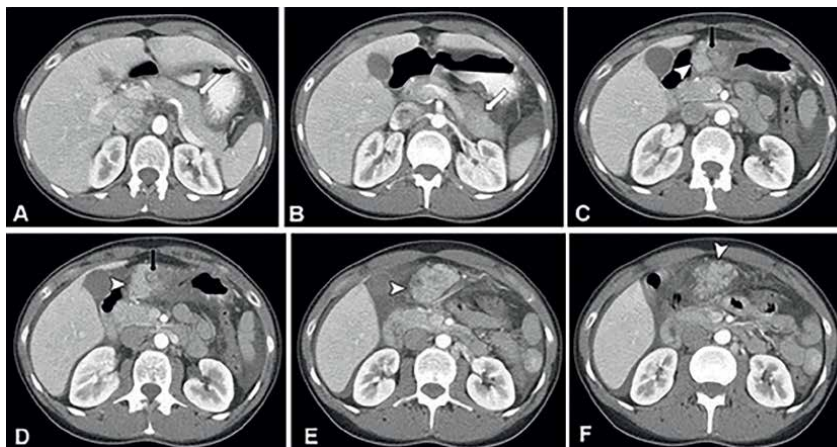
Heterotopic pancreas complication as acute pancreatitis in a 28-year-old woman with complaint of abdominal pain and nausea (elevated serum lipase level of 1300 U/L). Axial contrast-enhanced CT images show the orthotopic pancreas with a normal appearance (white arrow in A, B). A lobulated mass is seen expanding from the gastric antrum with a similar appearance to the orthotopic pancreas (arrowhead in C–F), with surrounding fat stranding and inflammation. There is also a lumen structure centrally (black arrow in C, D) [19].
